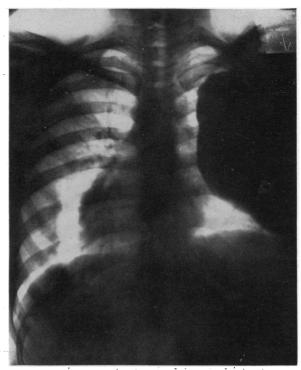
Case II. Anteroposterior X-ray following lipiodol injection showing the extent of the empyema cavity.
